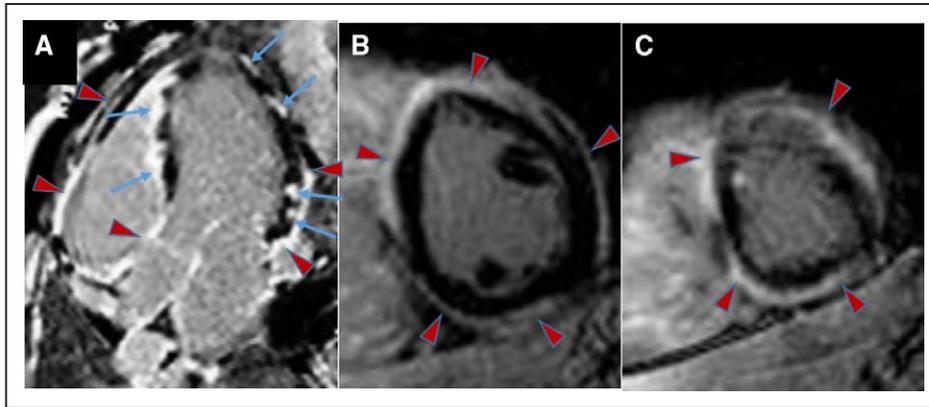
Cardiac sarcoidosis. A 33-year-old man who presented with the intermittent third-degree heart block and cardiac magnetic resonance imaging with late gadolinium enhancement demonstrating extensive cardiac involvement and sarcoidosis on lymph node biopsy. A (4-chamber apical view): patchy left ventricular (LV) lateral wall LGE and LGE of the right ventricular side of the ventricular septum with endocardial sparing (blue arrows). There is also LGE (red arrowheads) of the epicardium and pericardium of the basal to mid right ventricular (RV) free wall, atria, and LV pericardium. B (midventricular short-axis slice) and C (apical short-axis slice): extensive epicardial and pericardial (red arrowheads) LGE. Despite steroid therapy, he subsequently developed VT storm.
